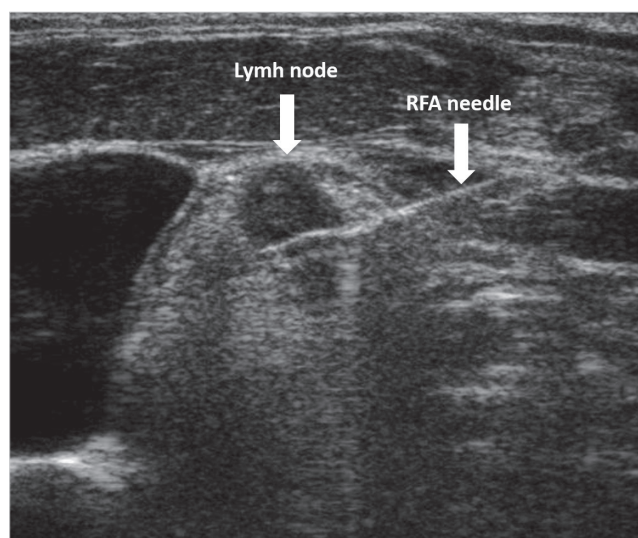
Ultrasonography image showing the metastatic lymph node that was adjacent to the jugular vein and radiofrequency needle.
